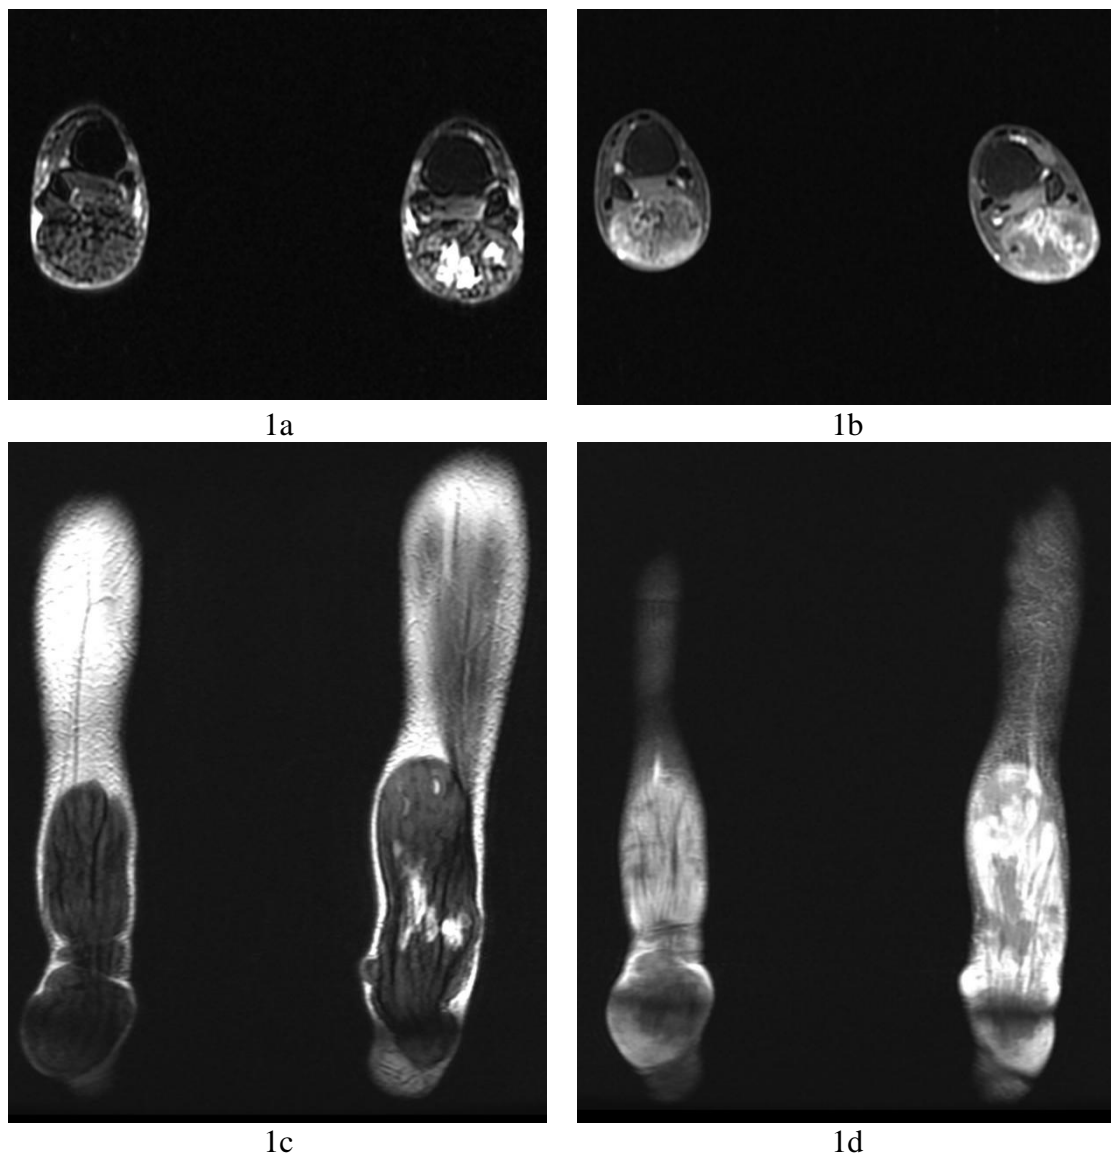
57-year-old male presented with bilateral swelling of the Achilles region. (a) Axial view of the bilateral lower limb MRI on T2WI showed two lobulated masses in the bilateral Achilles region with isointensity mainly and hyperintensity centrally. (b) Axial view of the same patient using gadolinium contrast showed heterogeneous enhancement within the bilateral Achilles tendons. (c) Coronal view of the MRI from the same patient on T2WI showed fusiform swelling of both Achilles tendons. (d) Coronal view MRI of the patient with gadolinium contrast showed heterogeneous
